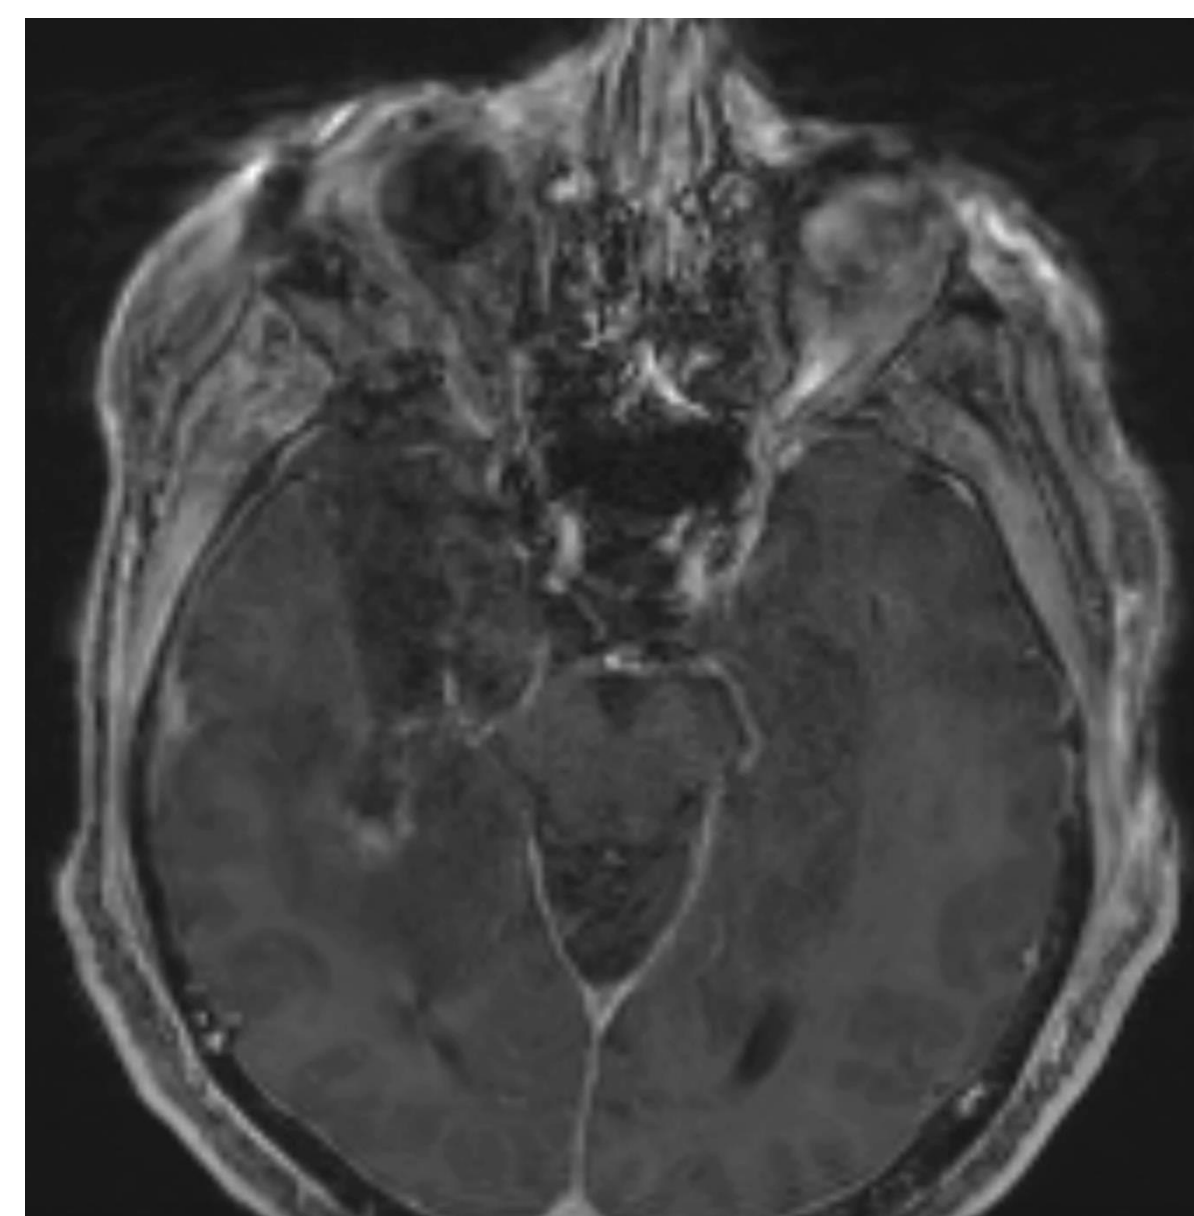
Postop axial T1 post-contrast MRI demonstrating gross total resection
